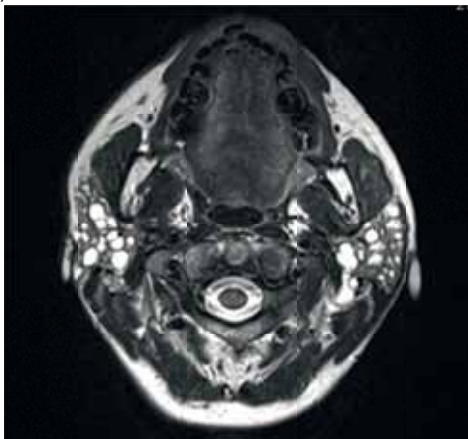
Axial MRI scan of progressed stage of SS (Source – own clinical material).
